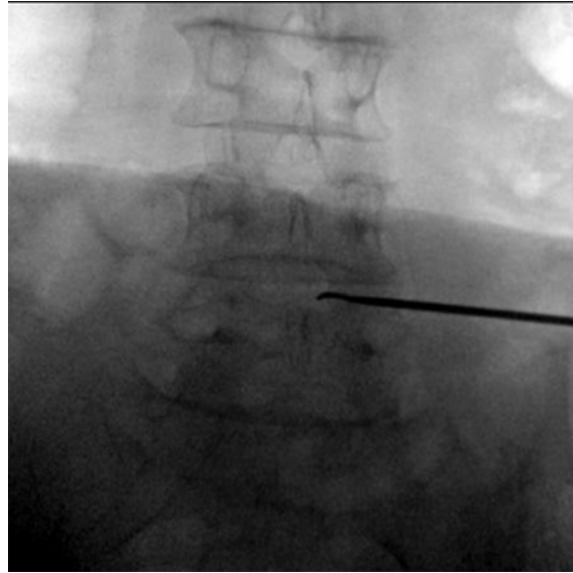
Antero-posterior view x-ray shows marking of L4-5 interlaminar window.
